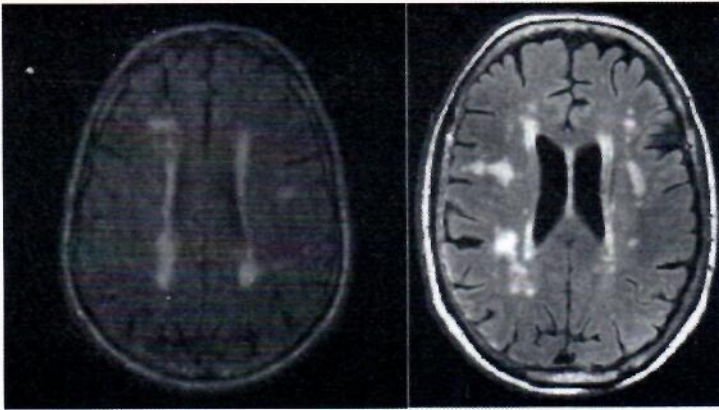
Axial Fluid Attenuated Inversion Recovery (FLAIR) MR images of the brain showing periventricular and deep white matter hyperintensities .
